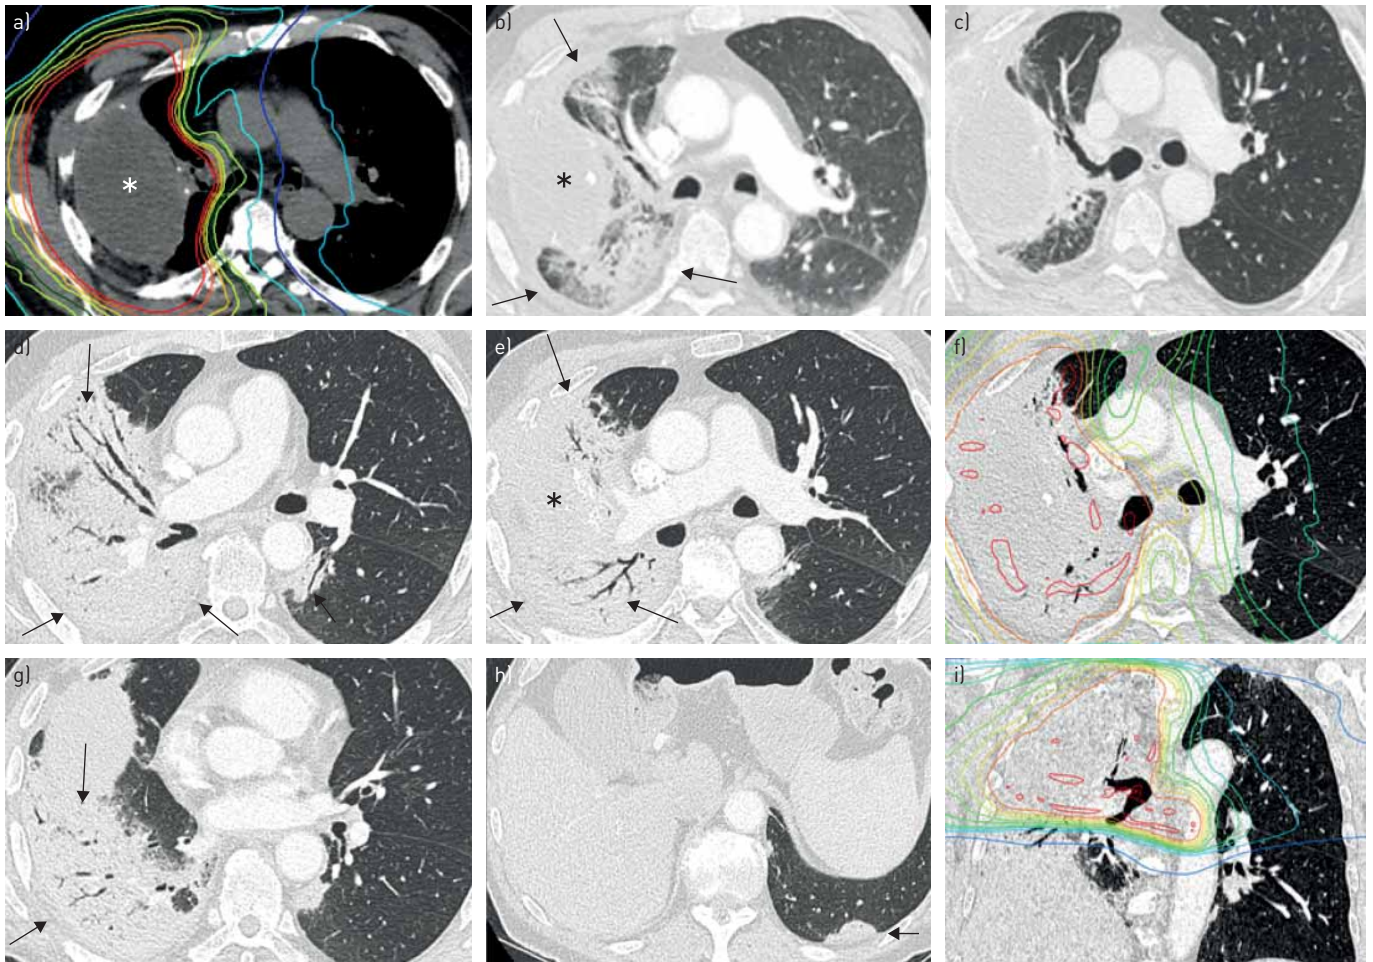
Immune-related pneumonitis grade 3 with organising pneumonia computed tomography (CT) pattern developed during nivolumab treatment in an 88-year-old man with non-small cell lung cancer infiltrating the third and fourth right ribs (cT3 cN1 cM0, stage IIIA). a) Radiation therapy field (*), 39 Gy in 13 fractions of 3 Gy (red: 50 Gy; blue: 5 Gy). b) CT scan performed 2 months after radiation therapy showing radiation-induced pneumonitis (arrows). Abnormalities in the contralateral lung are mainly due to poor inspiration. c) CT scan before starting nivolumab, 6 months after radiotherapy, showing almost complete resolution of the radiation-induced pneumonitis. After 4 months of nivolumab, the patient developed grade 3 dyspnoea. d and e) New alveolar and partly peribronchovascular consolidations (arrows) are visible. f) The consolidations are located within the radiation field, as revealed by the fusion CT-radiation therapy planning image (red: 50 Gy; blue: 5 Gy). However, g-i) some consolidations are also located outside the radiation field in the fusion CT-radiation therapy planning image (i, arrows), especially at the right lower lobe (g) and in a subpleural location on the contralateral side (h, arrow).
